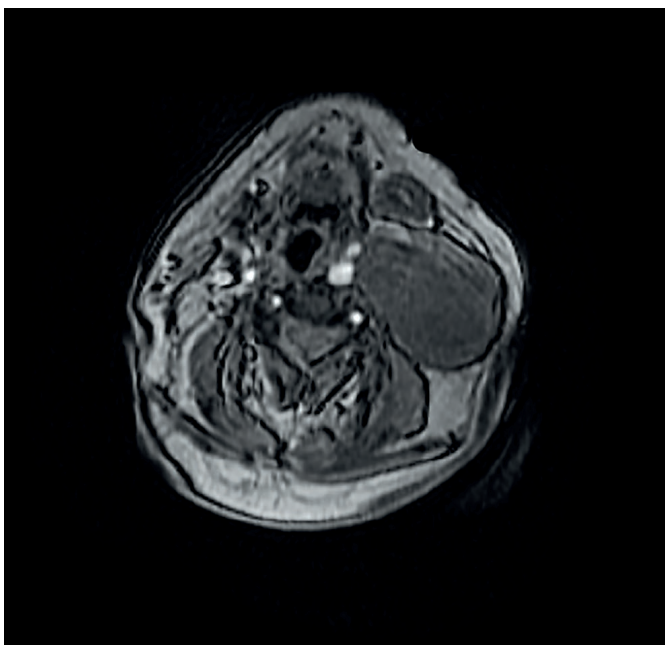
MRI scan (axial view) of the neck, showing a well-defined mass located in the left side deep to the sternocleidomastoid muscle near to the carotid artery.
